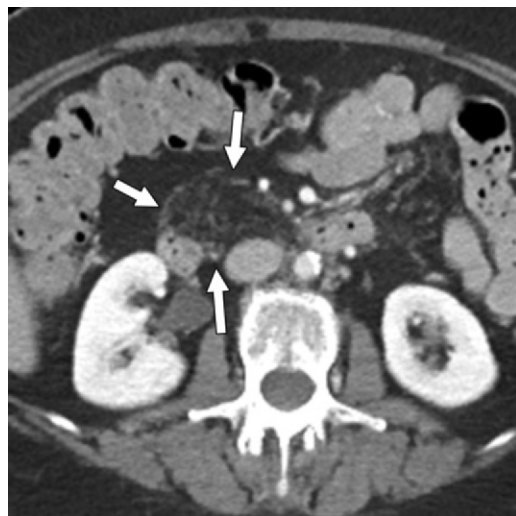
Focal fatty replacement of the pancreatic head in a 67-year-old woman. Axial contrast-enhanced CT image shows a fat-attenuating masslike structure replacing the pancreatic head (arrows). The mass appears heterogeneous and has a lacy appearance due to normal pancreatic parenchyma intermixed with fat.
